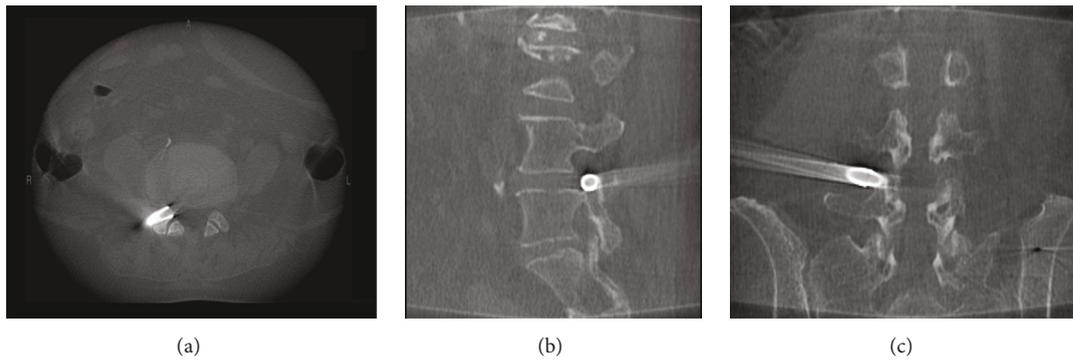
The axial (a), sagittal (b), and coronal (c) images of intraoperative CT re-scan during foraminoplasty.
